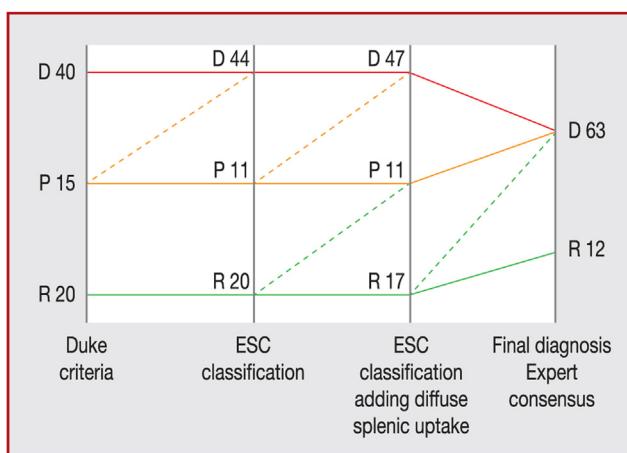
Reclassification of patients when adding positron emission tomography/computed tomography (PET/CT) findings. Infective endocarditis case reclassification according to the Duke criteria at admission, ESC classification and final diagnosis expert consensus at the end of the follow-up, showing the additional diagnostic input of PET/CT findings. D: definite; P: possible; R: rejected.
